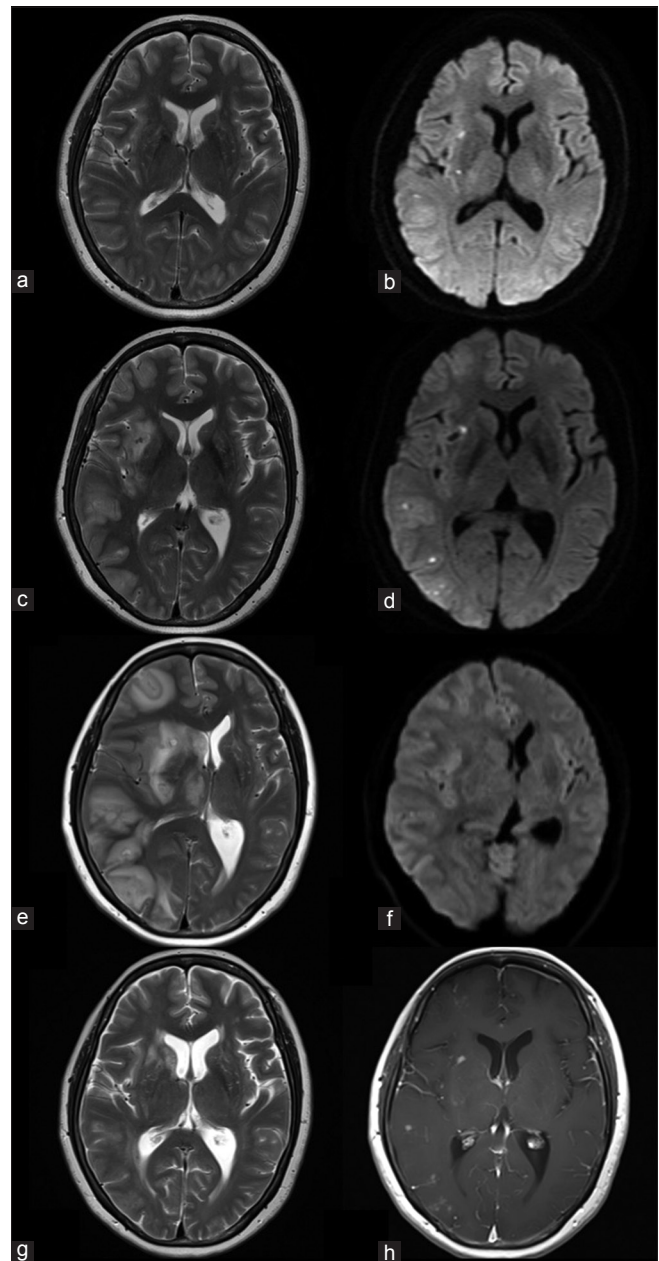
T2-weighted magnetic resonance imaging after the procedure showed no edema (a) and diffusion-weighted imaging showed a few hyperintensities in the right hemisphere (b). Magnetic resonance imaging 28 days after the procedure showed multiple edematous lesions in the right hemisphere (c), although there were no remarkable changes in diffusion-weighted imaging (d). Magnetic resonance imaging 42 days after the procedure showed a progression of edemas (e), though there were no remarkable changes on diffusion-weighted imaging (f). Magnetic resonance imaging after three courses of steroid pulse therapy (81 days after the procedure) showed a regression of edemas (g), and Gd-enhanced T1-weighted magnetic resonance imaging showed residual multiple enhancing lesions (h)
